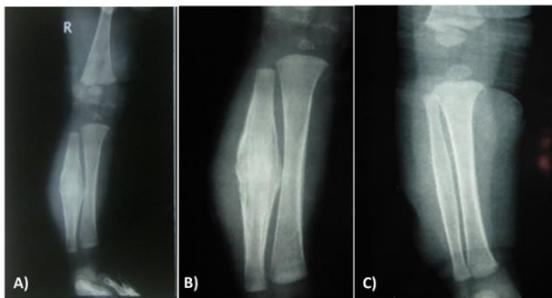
Serial X-ray pictures of the child showing progression of the disease, A) X-ray at the time of presentation showing diffuse thickening of fibula with periosteal reaction, B) X-ray of the same child after 3 months of onset of disease showing increase in the size of bones with periosteal reaction, C) X-ray after one year showing healing of the disease
